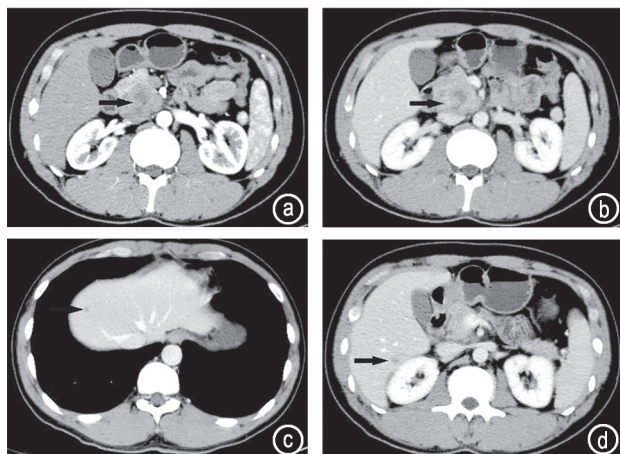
CT findings before therapy. (a–b) Abdominal CT showed a heterogeneous, liquefactive necrotic mass in the uncinate lobe of the pancreas on contrast CT. The lesion showed a mild enhancement of solid components and pancreaticoduodenal artery across the mass on the contrast CT; (c–d) There were two low density lesions in the right lobe of the liver and the lesion showed a mild enhancement on the contrast CT
